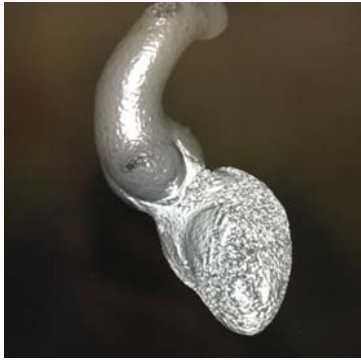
CT thoracic aorta pre-operatively demonstrating isolated aortic root dilation measuring 4.8 cm.
